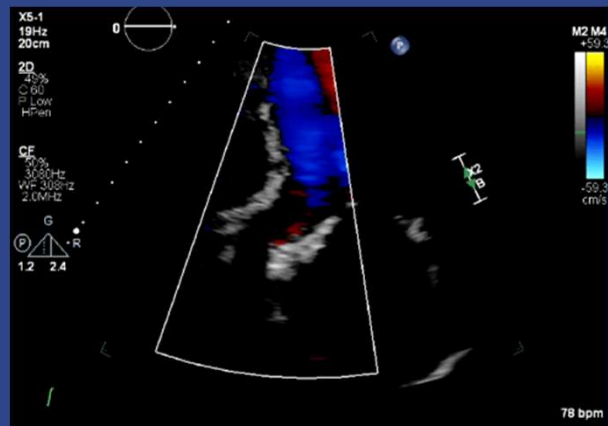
LVOT outflow apical five, from author's clinical collection, de-identified (M.Trump, 2025)
